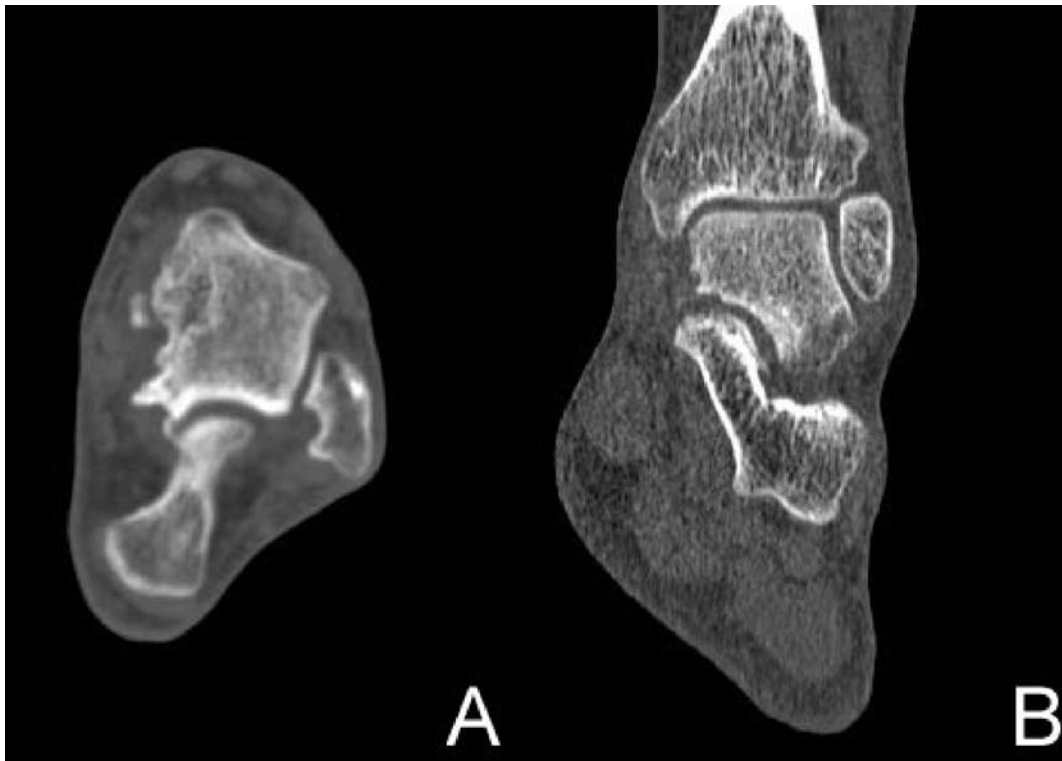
Multislice computed tomography images showing the patient's ankle joint after excision of the posteromedial fragment in axial view (A) and coronal view (B).
